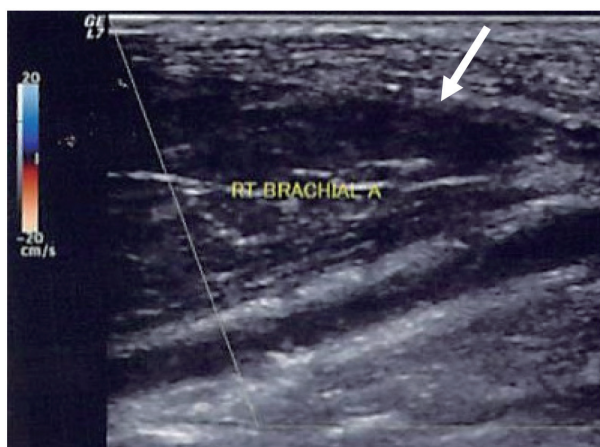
Duplex-sonography before the revascularisation surgery. Duplex-sonography showing the lack of blood flow in the right brachial artery (arrow) at a slightly proximal level relative to the right elbow.
